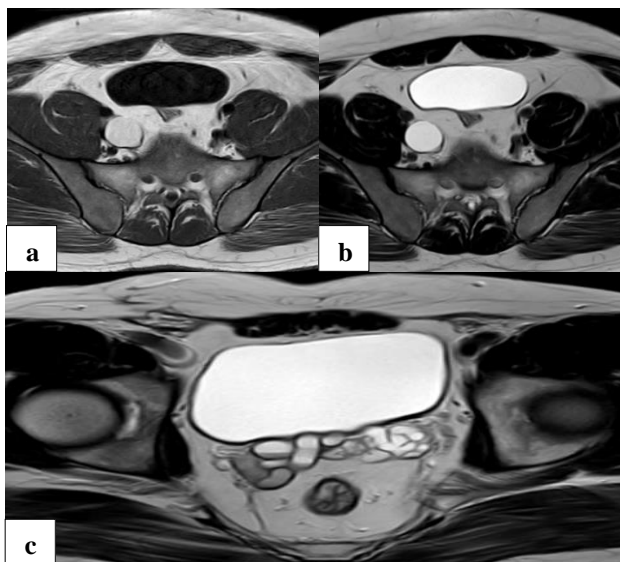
(a and b): MRI axial images showing a well-defined round to oval shaped T1 hyperintense, T2 hyperintense lesion with fluid-fluid level in the pelvis posterior to the bladder, s/o seminal vesical cyst; and (c) MRI coronal image showing dilated tubular structure showing T2 hyperintensity with fluid-fluid level (T2 shading sign), s/o dilated ejaculatory duct.
